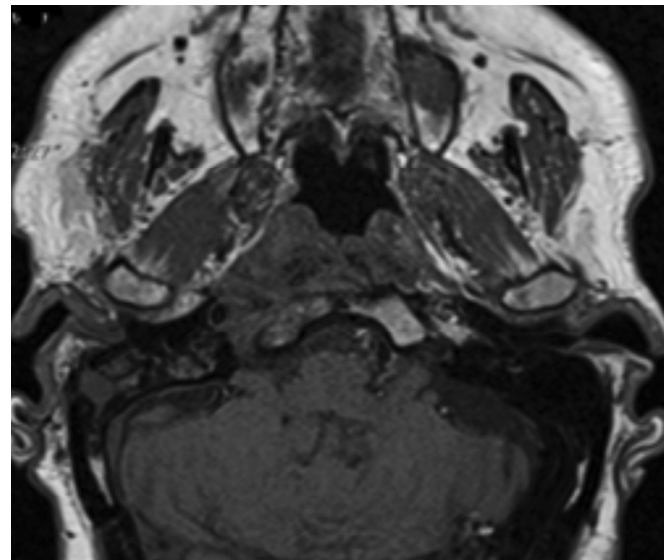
Surveillance MRI at six weeks: There is significant improvement of the inflammatory changes in the right side of the central skull base. There is a small area of marrow oedema and enhancement within the right petroclival region, which as previously demonstrated involves the walls of the carotid canal. There is a small area of enhancing soft tissue in the right nasopharynx. This still obstructs the right eustachian tube as evidenced by effusion in the right middle ear.
